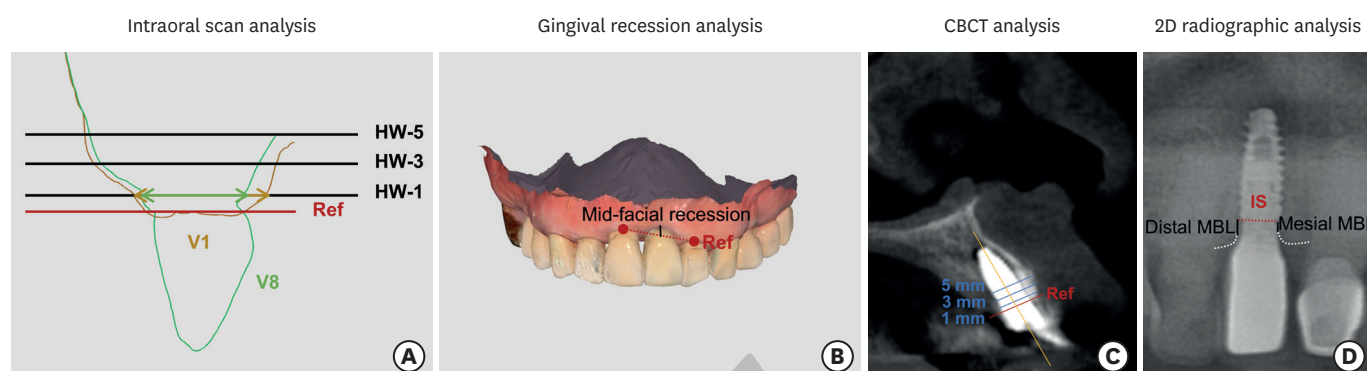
Methods for evaluating intraoral scans and radiographs. (A) Intraoral scan analysis. STL files were superimposed at different time points using adjacent teeth as reference points. The HW was measured at 1 (HW-1), 3 (HW-3), and 5 (HW-5) mm below the reference line. (B) Gingival recession analysis. Midfacial gingival recession was measured as the perpendicular distance from the most apical point of the implant crown to a reference line drawn through the gingiva of the adjacent tooth. (C) CBCT analysis. Two CBCT images were superimposed using specialized software. Buccal bone thickness and buccolingual width of the alveolar bone around the implant were measured using a reference line (red; Ref) at the implant shoulder level, with additional lines (blue) drawn 1, 3, and 5 mm below it. The alveolar bone ridge width was measured along these lines, and buccal bone thickness was calculated by subtracting the ridge width from the distance between the inner buccal bone surface and the outer palatal bone wall. (D) 2D plane radiographic analysis. MBL changes were evaluated by comparing panoramic radiographs taken immediately after implant prosthesis delivery (V6) and at 450 days post-placement (V8). The mesial and distal distances (black line) between the IS (red dotted line) and the first bone-to-implant contact (white dotted line) were measured. MBL changes were calibrated using the known implant lengths. HW: horizontal alveolar ridge width, CBCT: cone beam computed tomography, 2D: 2-dimensional, MBL: marginal bone level, IS: implant shoulder.
